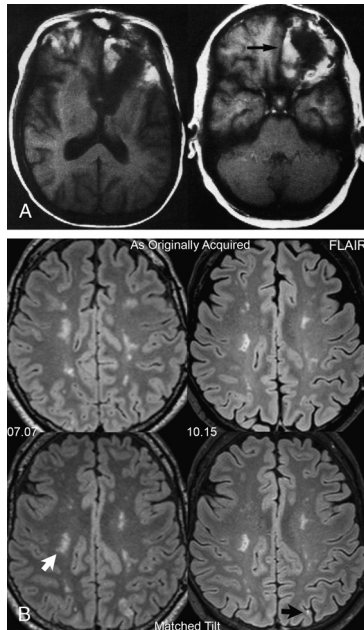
Then and now, standardization of image tilt. As early as 1987, inconsistent head positioning was recognized as a problem in clinical imaging, with suggestion of standardization using a tilt in the axial plane. In the example presented (A), improved depiction of enhancing tumor (arrow) is noted in the low left frontal lobe with this approach. Standardization of imaging plane is an important key today to good clinical practice (B), with automatic image alignment (if implemented by the technologist) as a standard part of prescan adjustments. Watershed infarcts are presented on FLAIR images from an examination the week after clinical presentation (left column) and at 3 months (right column). Images in the upper row are the original axial reformatted images from the 3D data sets; the images in the lower row are reformatted to match imaging plane for the 2 examinations. Note that by standardization of the displayed imaging plane, the larger deep white matter infarct on the right (white arrow) can now be easily identified on the follow-up examination, and its evolution assessed, with gliosis replacing the previously identified edema, in a slightly smaller area of involvement, with central cavitation. Comparison of a cortical lesion in the superior parietal gyrus on the left (black arrow), now enabled by the standardization of the presented axial plane, reveals extensive resolution of edema with only a pinpoint area of gliosis remaining. Reprinted with permission from Runge et al (*Magn Reson Imaging*. 1987;5:421–430) and Runge (*Imaging of Cerebrovascular Disease*. New York, NY: Thieme Medical Publishers [in preparation]).
